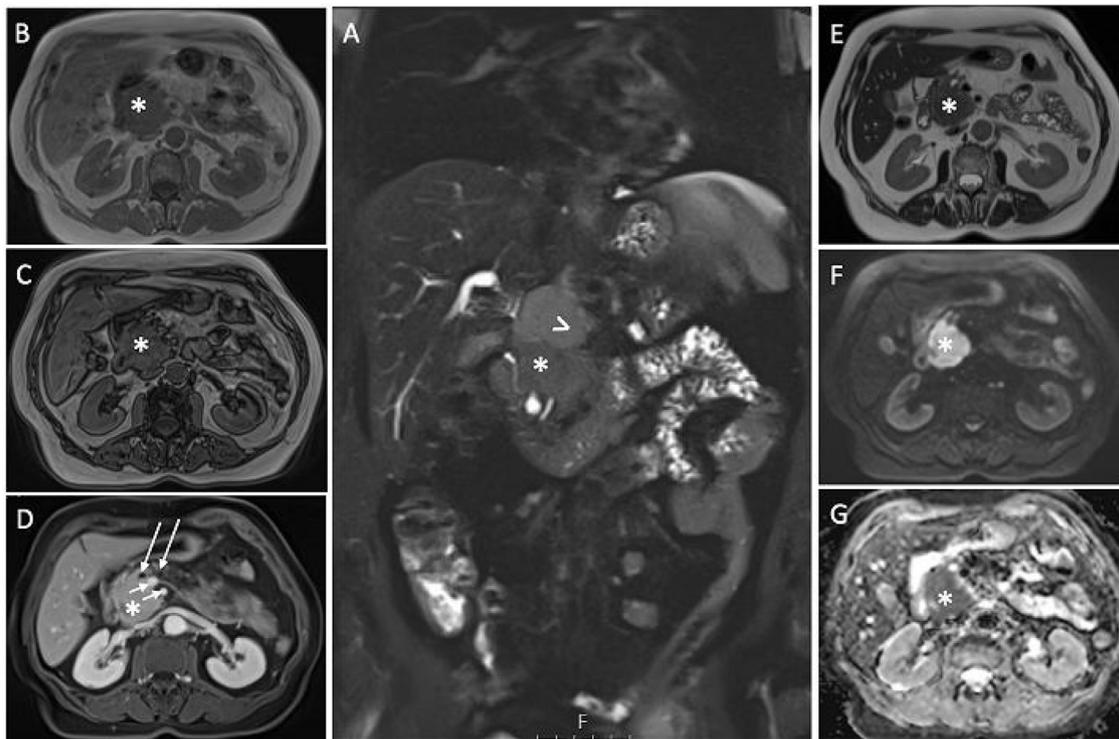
Coronal and axial T2W MRI scans, showing a mass in the pancreatic head (A-E-asterisk), with intermediate signal intensity, accompanied by peripancreatic lymphadenopathy just superior to the mass, demonstrating slightly less signal intensity than the mass (A-arrowhead). The mass shows hypointense signal characteristics on the non-contrast T1W in-phase and out-of-phase MRI scans (B-C) and demonstrates subtle contrast enhancement (D-asterisk). Note the patency of the superior mesenteric artery and the splenic vein (D-short arrows) and the slightly dilated ductus pancreaticus on the post-contrast T1W image (D-long arrows). Lastly, axial DWI and corresponding ADC images show homogeneous diffusion restriction of the primary mass (F-G-asterisk).
